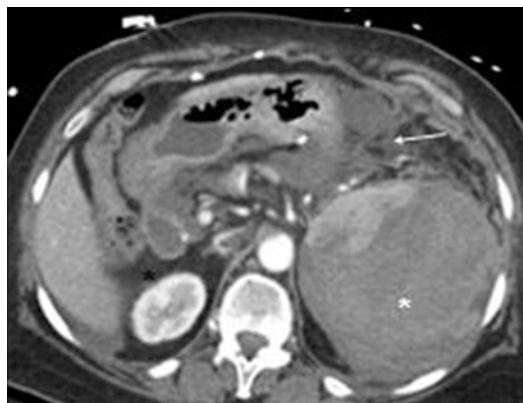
Traumatic splenic rupture following colonoscopy in a 60-year-old man. Axial abdominal CT image with intravenous contrast shows a large subcapsular splenic hematoma, compressing the spleen, which is small and anteromedially displaced (asterisk), with blood extending along the stomach and pancreas (arrow)
